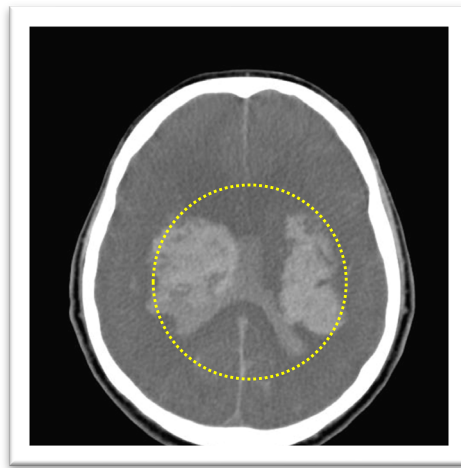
Brain CT of Case 4 shows bilateral periventricular and intracranial hemorrhage (as highlighted by yellow dotted circle).
